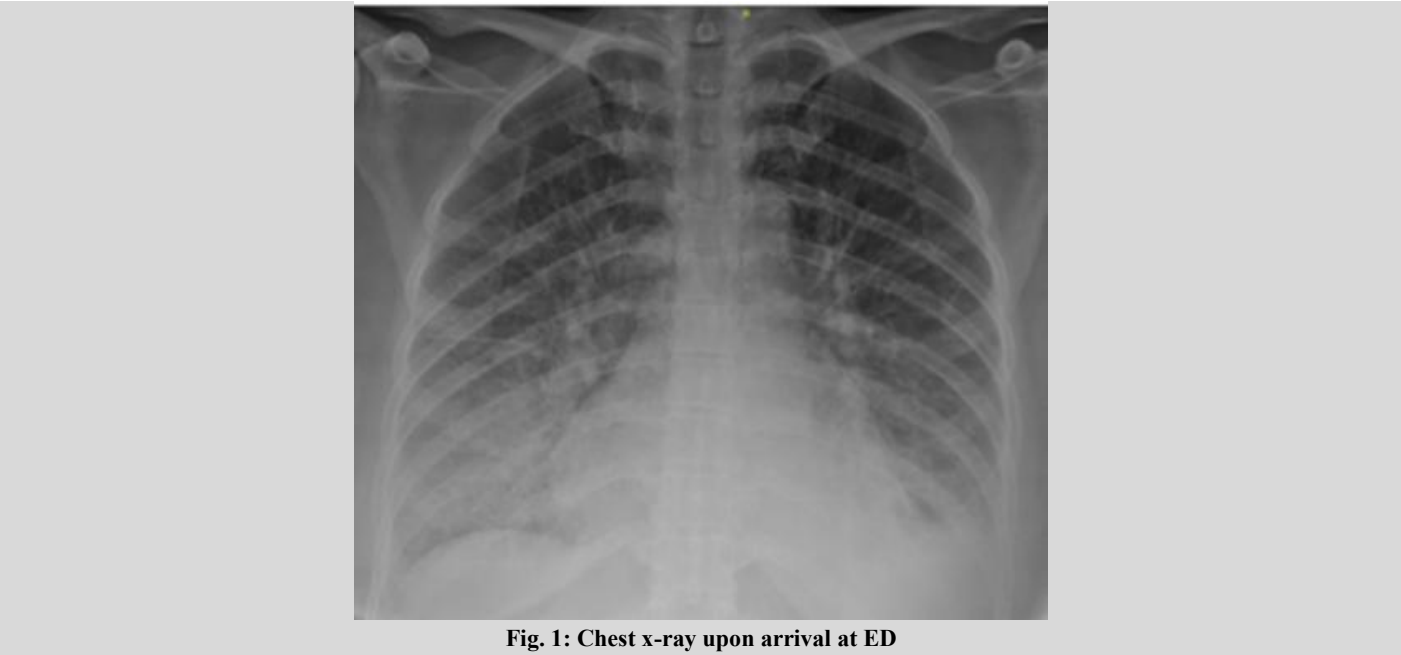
Chest x-ray upon arrival at ED
